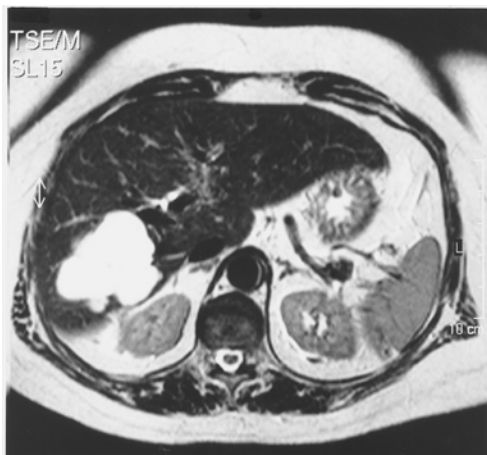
Magnetic resonance image of a conservatively treated patient, showing a typical lobulated hyperdense lesion on T2-weighted sequences, characteristic of a haemangioma.
